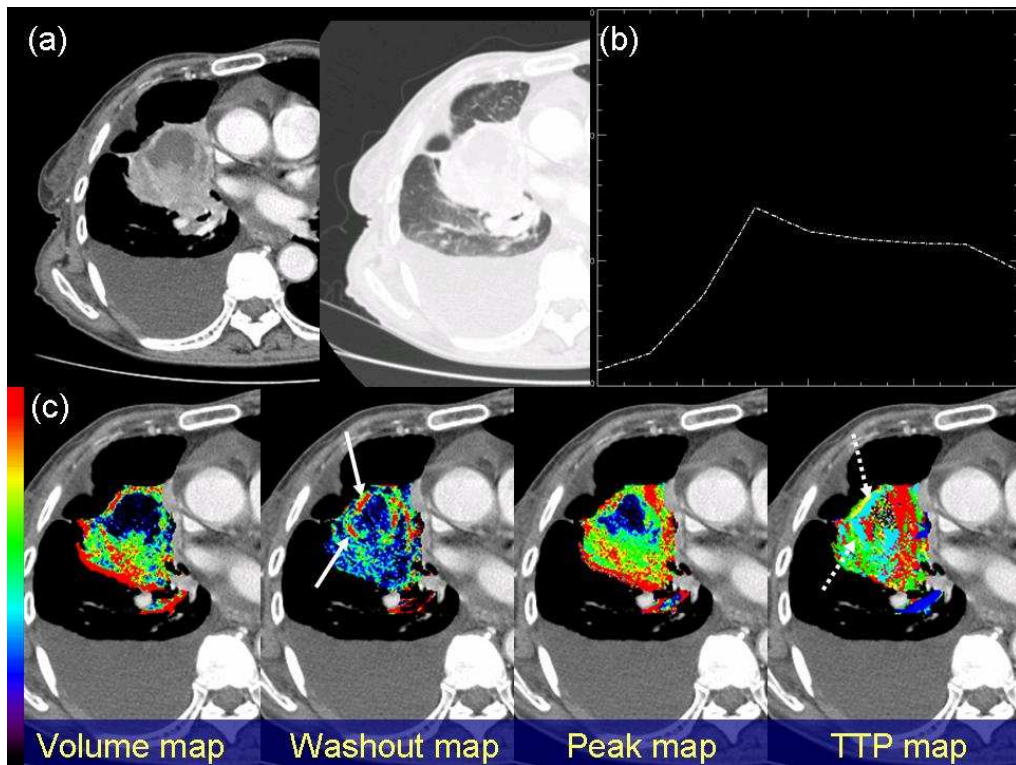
Chest CT and parametric perfusion maps in a 71-year-old woman with adenocarcinoma in the right middle lobe.
